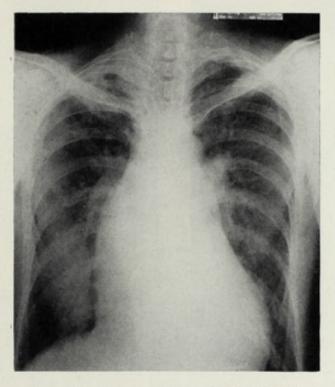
The x-ray film of this 49-year-old man (B. L. 195805) shows prominence of the pulmonary artery and inconspicuous dilatation of the ascending aorta. These features, together with the murmur of aortic regurgitation and the associated Austin Flint murmur, lead to the diagnosis of rheumatic heart disease with combined aortic and mitral lesions. This was the case in spite of the fact that the patient was $75\frac{1}{2}$ inchest tall, had spinal and thoracic deformities (a suggestion of which is indicated by the figure), and had had ectopic lenses removed 10 and 13 years previously. The patient had pneumonia twice in youth and had an operation for varicose veins at the age of 25 years. Scholastic performance was outstanding, with graduation from college at the age of 18 years. A bout of iritis prompted removal of the right lens in 1937. In 1940 the left lens was removed because of dislocation into the anterior chamber. Detachment of the retina on the left was discovered at that time. There was heterochromia iritis with normal brown pigmentation on the right and greenish coloration on the left. The patient was accepted for service in the Army and, while there (1947), had his first bout of severe chest pain with extension to the arms, neck, and epigastrium. A second episode of probable aortic dissection occurred later in 1947 and a third in 1948. The episode in 1948 was characterized by severe low back pain radiating into the lower abdomen and genitalia. The diagnosis of rheumatic heart disease was based on the prominence of the pulmonary artery segment (due actually to displacement by the dilated aorta), a diastolic murmur at the apex (which was probably either radiation of the esophagus by what was interpreted as left atrium (possibly indeed left atrium enlarged from chronic left ventricular failure or possibly the aortic aneurys, see Fig. 21E). The patient died at home in 1950.
